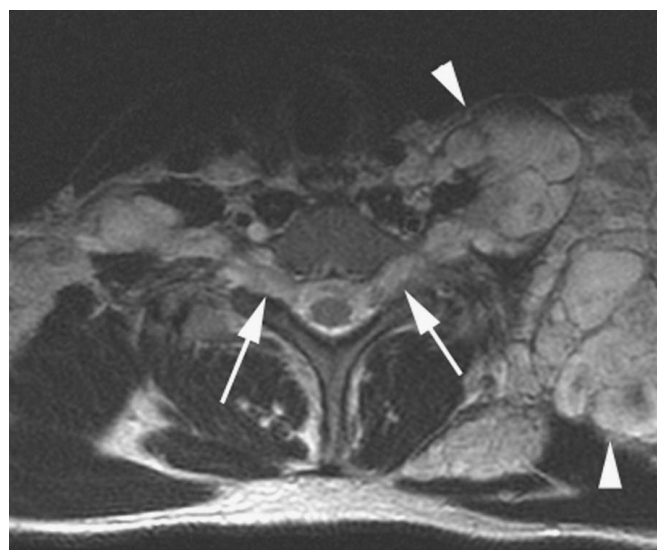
NF-1. Axial T2-weighted image demonstrates extensive plexiform neurofibromas involving the bilateral brachial plexi (arrows), axilla (arrowhead), and left chest wall (arrowhead).
